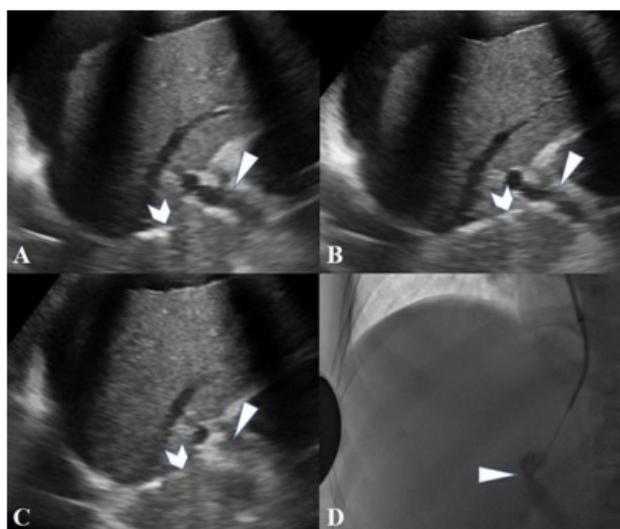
Ultrasound (US)-guided portal vein access and injection of saline to confirm the IV placement. (A) Needle (white arrowhead) targeting toward the right portal vein (white triangle) under US guidance. (B) US-guided advancement of needle (white arrowhead) into right portal vein (white triangle). (C) Agitated saline is injected to confirm the portal entry, shown as a cloud of echoes by sonogram (white triangle). (D) Injection of contrast agent to re-confirm the portal entry (white triangle).
